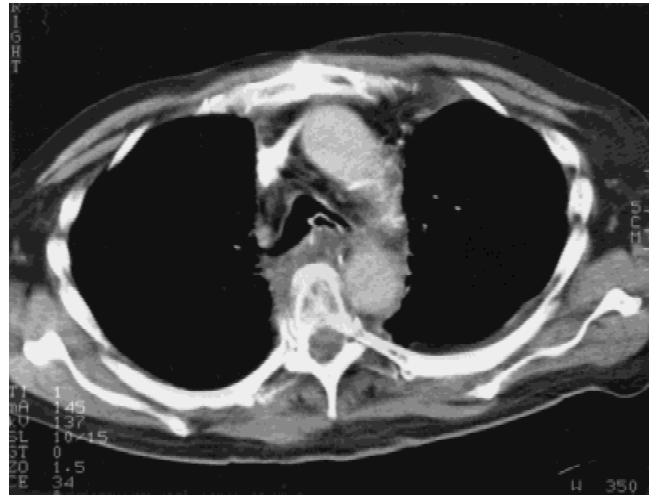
CT scan at 22 months postesophagectomy demonstrating the Goretex patch narrowing and within the left mainstem bronchus. No evidence of tumor recurrence is visible.
